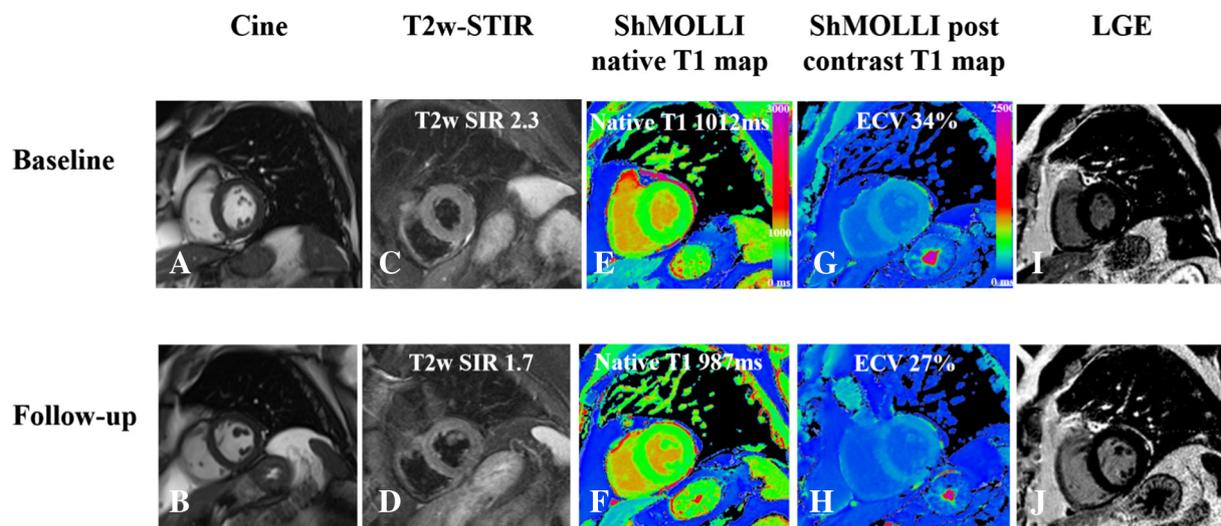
Effect of anti-TNF therapy on myocardial tissue characteristics. Cine image before (A) and after (B) anti-TNF therapy. T2-weighted images before (C) and after (D) anti-TNF therapy. The T2 SIR improved from 2.3 to 1.7 following anti-TNF administration. Native T1 image before (E) and after (F) anti-TNF therapy. Mean native T1 values improved from 1012 ms to 987 ms following anti-TNF administration. Postcontrast T1 image before (G) and after (H) anti-TNF therapy. Mean postcontrast T1 values increased from 367 ms (ECV 34%) to 422 ms (ECV 27%). LGE image before (I) and after (J) anti-TNF therapy.
